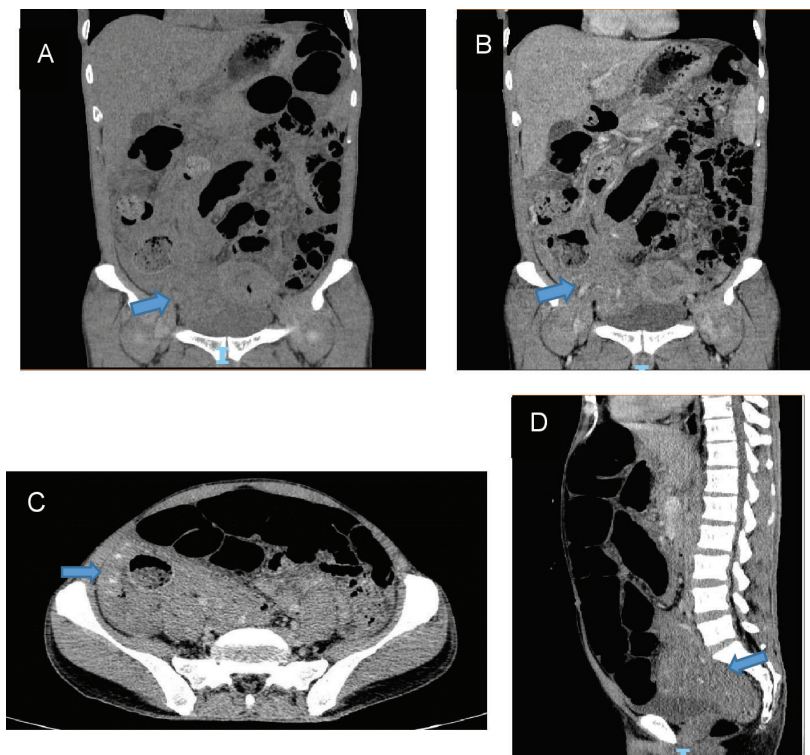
(A) Non-contrast - abdominal computed tomography (CECT). (B, C, D) Contrast enhancement computed tomography in coronal, axial, sagittal show a dense tissue replacing mesenteric fat, surrounding loops of bowel
